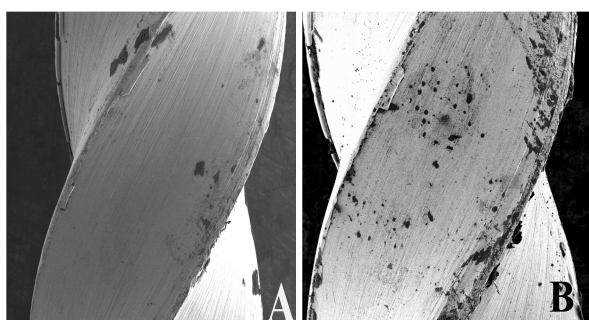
More contamination at D16 part of instrument after ultra-sonication (A) before cleaning (B) after ultrasonic cleaning ($\times 150$)
